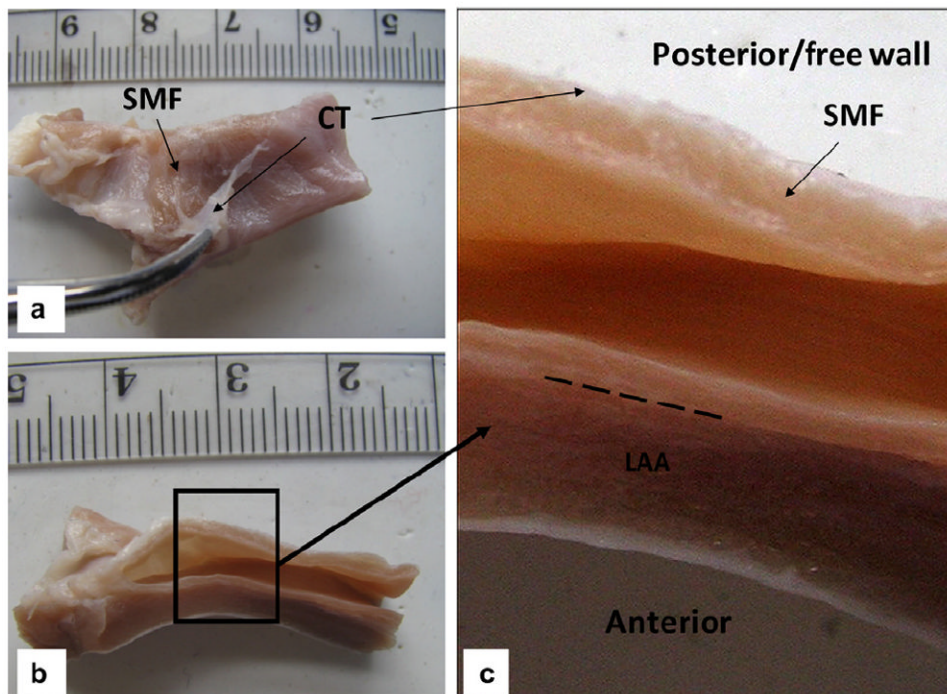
(a) Coronary sinus (CS) vessel fixed in 10% formalin for 2 days, with the connective tissue (CT) peeled off to expose the striated myocardial fiber (SMF) layer; (b) axial view; (c) a closer view of the CS inner wall with distinctive layers of SMF, CT and left atrial appendage (LAA). The long dashed line indicates the barrier between the CS wall and LAA.
